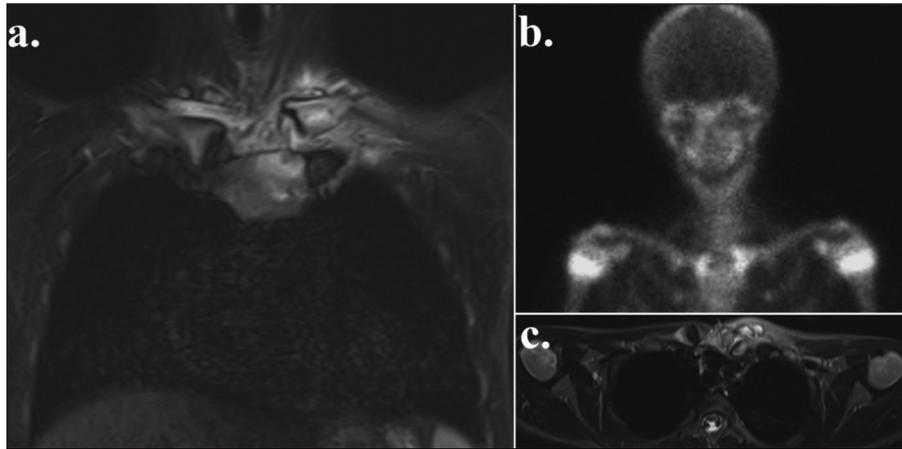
a) T2 weighted magnetic resonance images in coronal plane revealed increased synovial fluid in left sternoclavicular joint with marrow edema suggesting osteitis/osteomyelitis; b) fluid accumulation and synovial hypertrophy resulted in cyst like appearance anterior to the sternoclavicular joint in the horizontal plane; c) bone scintigraphy revealed increased activity in left sternoclavicular joint.
